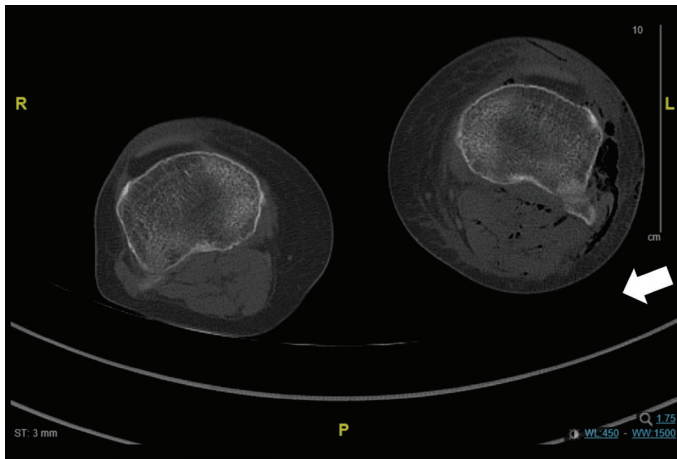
Lower extremity computed tomography
